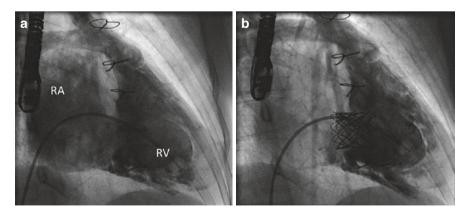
Transcatheter valve-in-valve implantation of a Melody® valve system into a failing tricuspid valve prosthesis. The patient with Ebstein anomaly presented with severe regurgitation of the bioprosthesis only 3 years after implantation (a). The final angiogram (b) showed valve competence and transoesophageal echocardiography did not show significant stenosis
